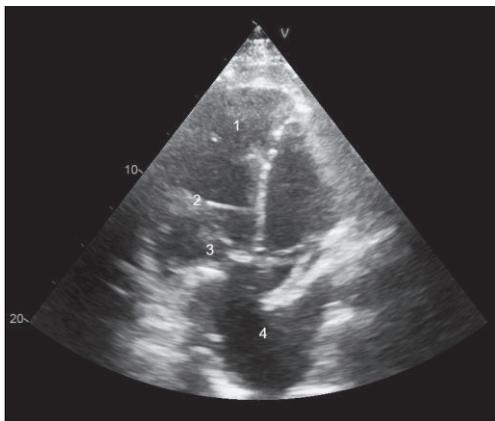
Transthoracic echocardiography of patient 1 after VAD implantation
